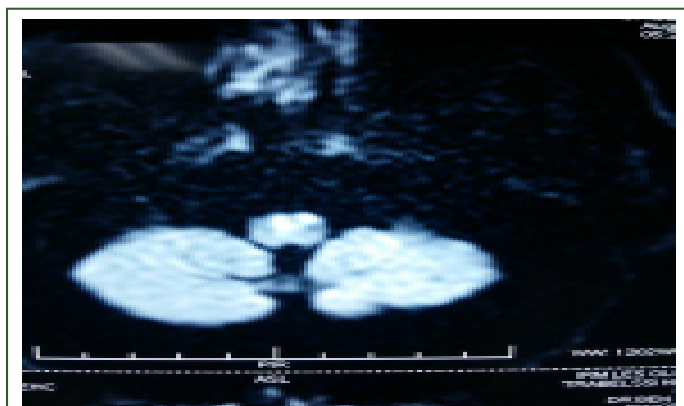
MRI sections in axial sequence (Flair and diffusion), sagittal section respectively showing bilateral anterior bulbar ischemic.
